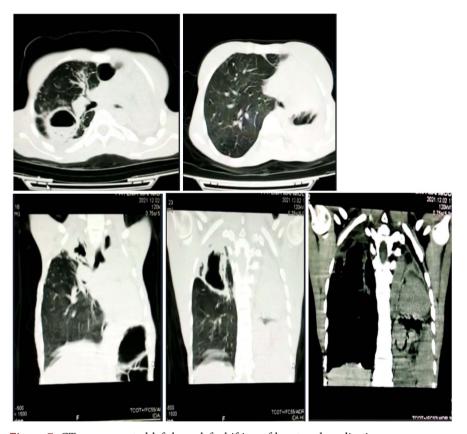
CT scan: resected left lung, left shifting of heart and mediastinum, compensatory inflation of right lung with same bullae in the apex.
